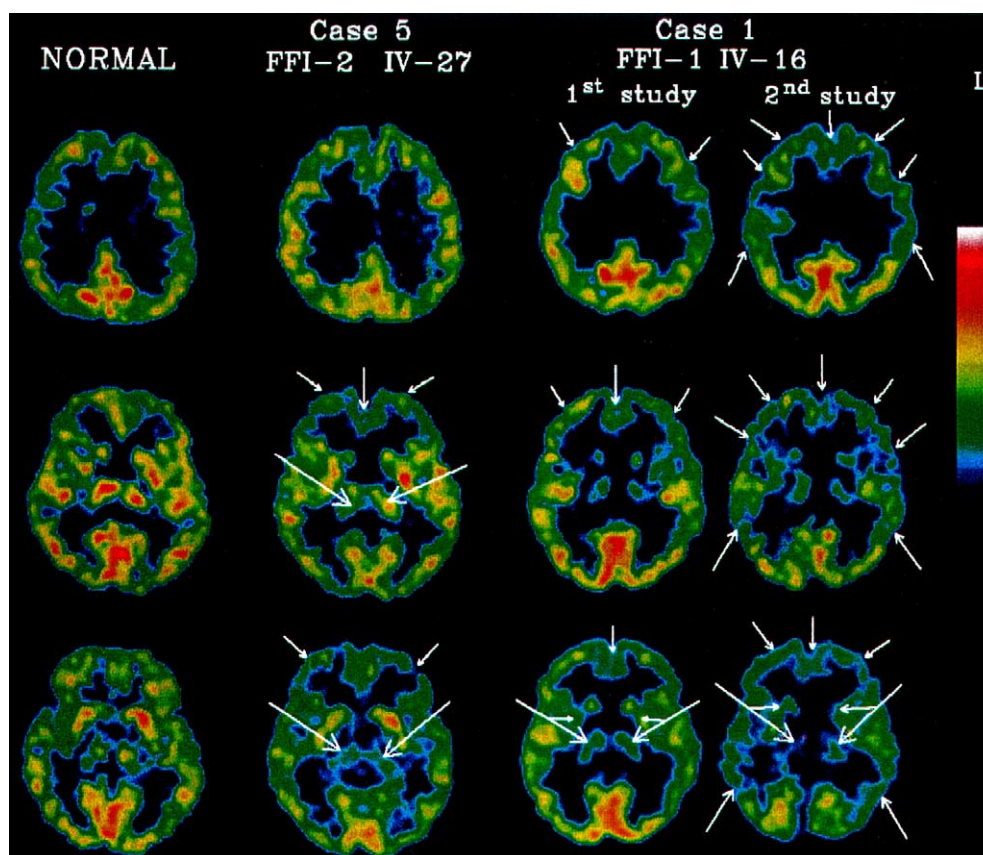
[18F]-FDG PET in a normal subject and FFI patients with a short (case 5) or long-lasting (case 1) disease course, showing hypometabolism in both thalami in case 5, associated with cortical frontal, cingular and temporo-parietal hypometabolism (arrows) more prominent in case 1. With kind permission from Cortelli et al. (1997).
